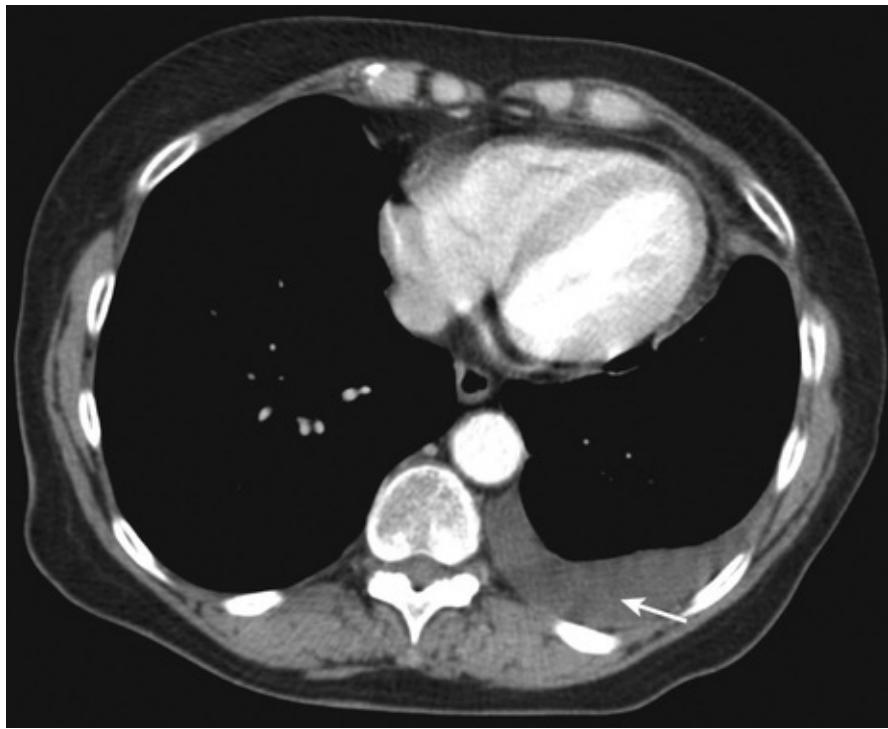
CT of a 48-year-old man who presented with increased breathlessness. The patient is lying on their back and a dark grey area can be seen at the posterior part of the left lung with smooth concave edges (arrow). This is a simple pleural effusion showing the CT appearance of the 'meniscus sign'.
